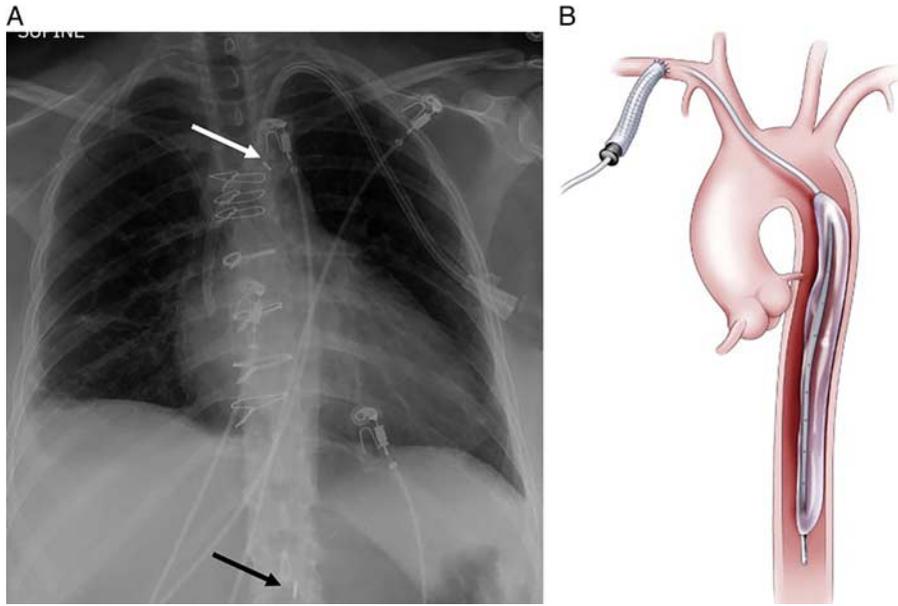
Right subclavian artery approach IABP. A, Frontal radiograph depicting right subclavian artery approach IABP. Note the smaller comma-shaped marker (white arrow) is just below the aortic arch, whereas the larger marker is below the diaphragm (black arrow), because of inverse placement. B, Subclavian IABP (used with permission).
